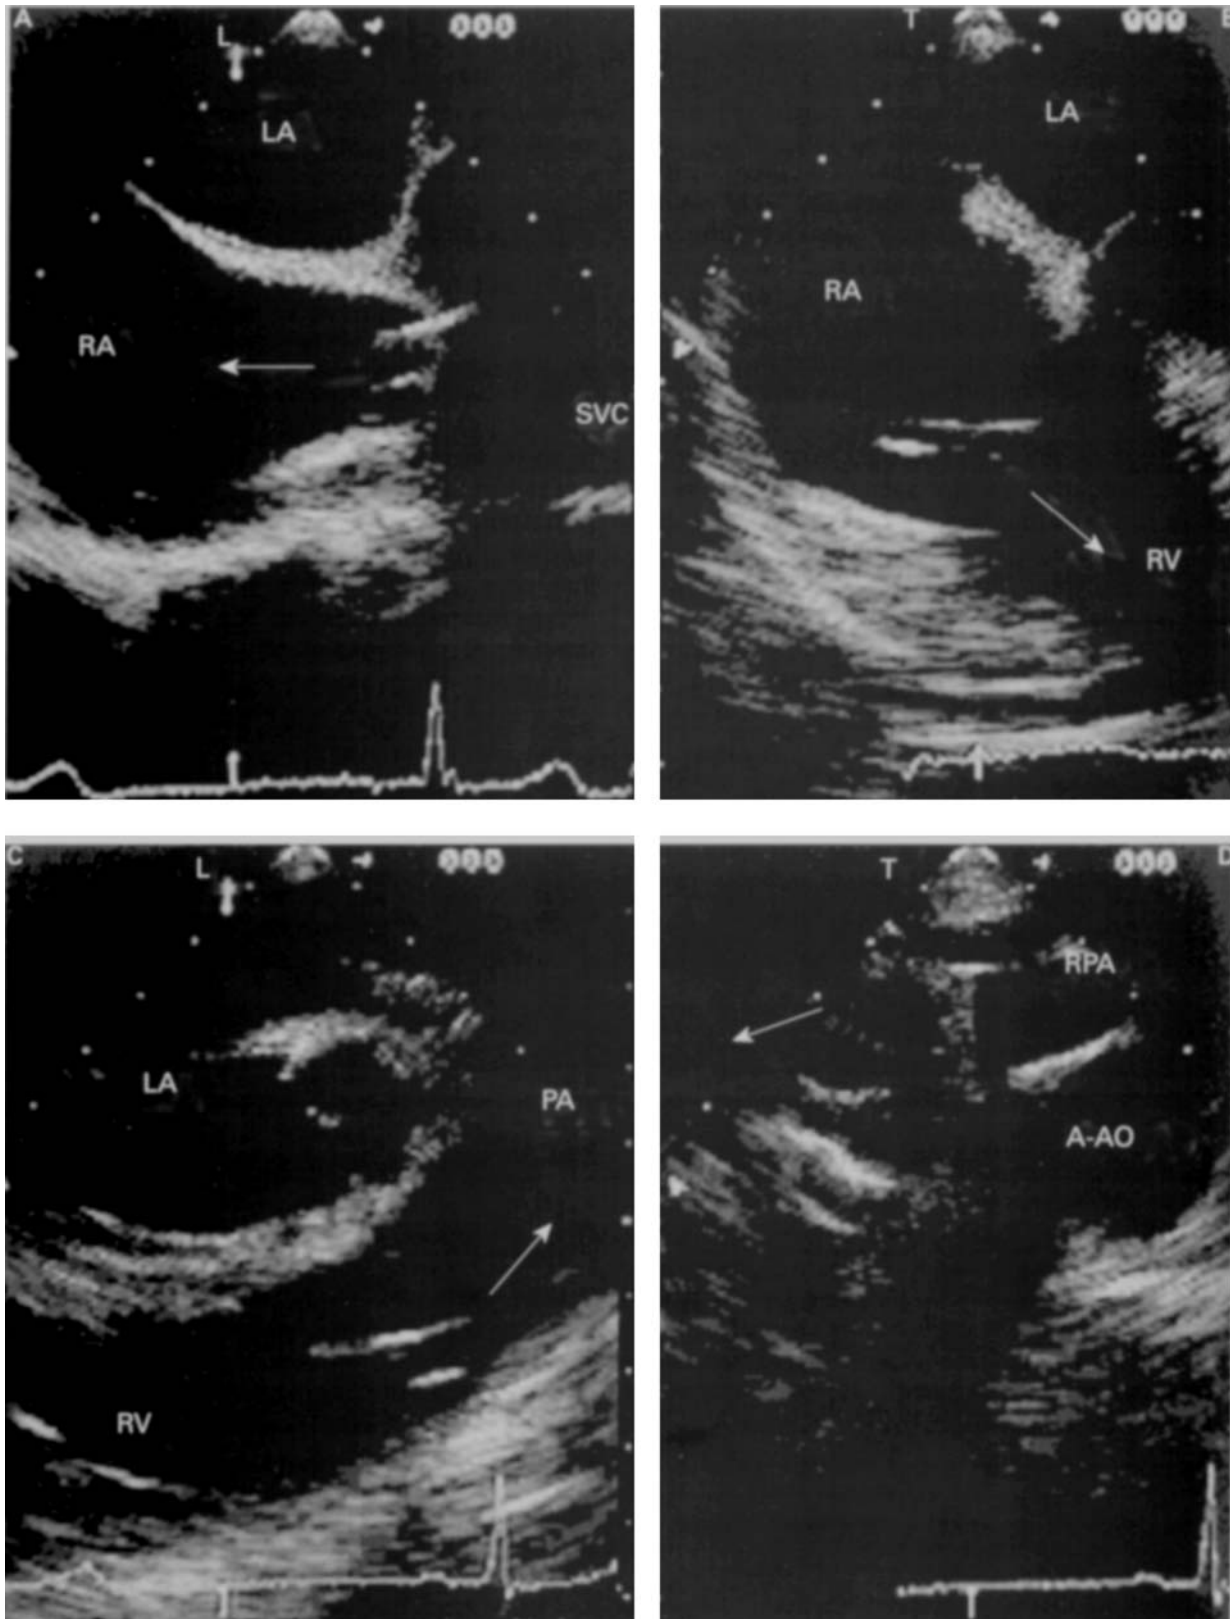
Transoesophageal echocardiogram showing process of pulmonary artery (PA) catheter placement: (A) from superior vena cava (SVC) to right atrium (RA); (B) from RA to right ventricle (RV); (C) from RV to PA; and (D) advancement in the right pulmonary artery (RPA). A-AO = ascending aorta, LA = left atrium.
